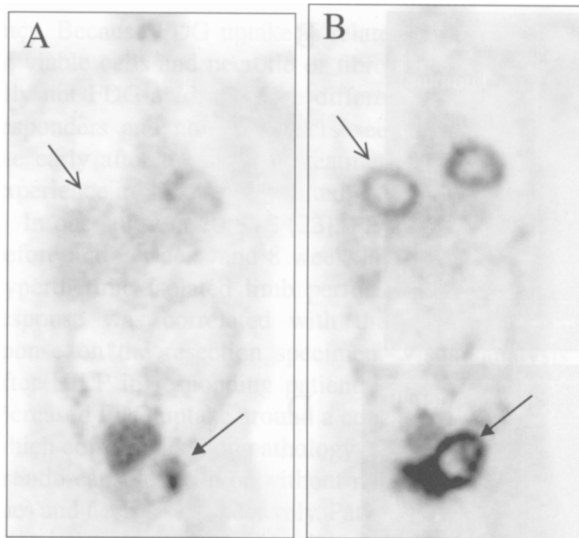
Suspicion of secondary resistance on CT after 18 months of imatinib mesylate treatment (2×400 mg) (data not shown, same patient as in Fig. 4). On PET only the pelvic mass showed increased FDG uptake, suspected for recurrence, while the liver metastasis were still not metabolically active (A). One week after the discontinuation of imatinib mesylate treatment, PET showed a major increase in tumour volume of the pelvic mass and the liver metastasis became metabolically active again (B), suggesting still some residual effect of imatinib mesylate even in apparently resistant disease.
